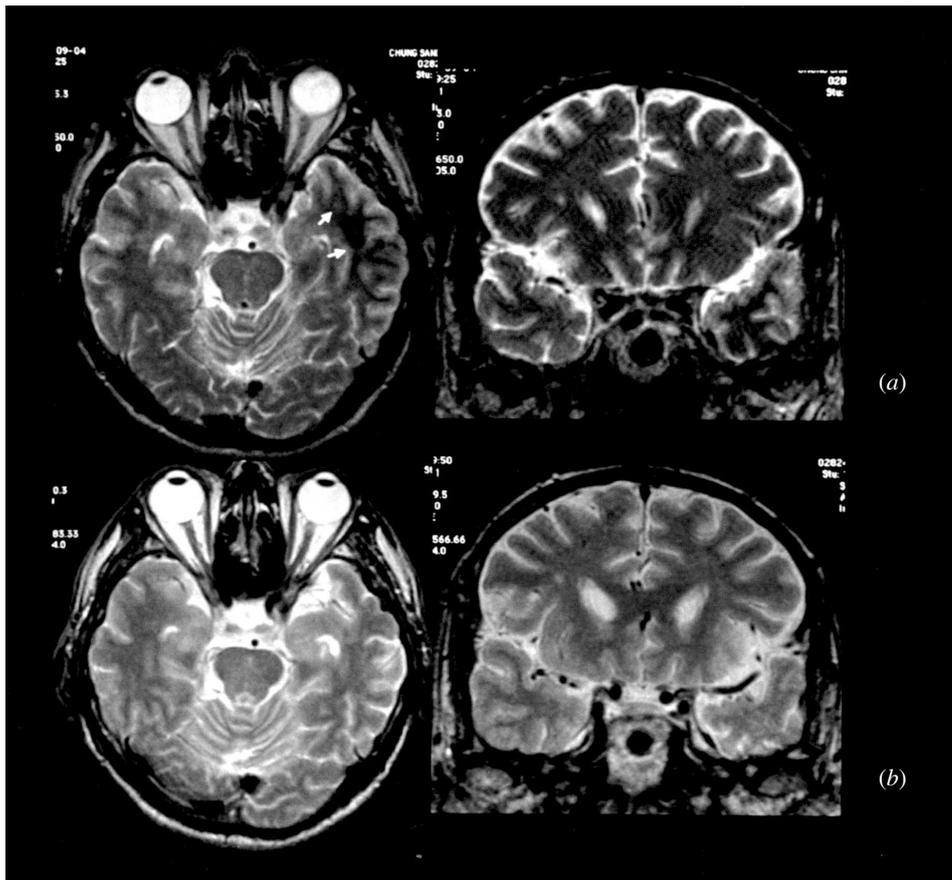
Brain MRI was performed during admission (a) and 4 months later (b). Initial T2 MRI shows no structural abnormalities except for a low signal area in the left temporal lobe (arrow) which disappeared on the follow-up MRI.
